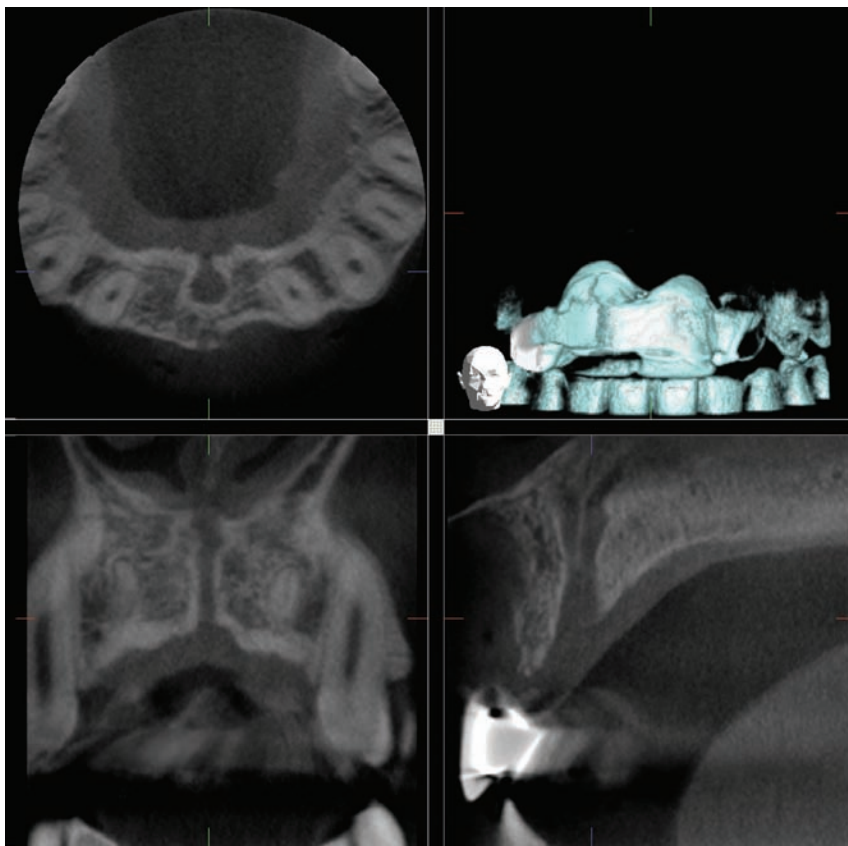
A series of cone-beam CT sections of the incisive canal. The upper left shows the canal in the axial plane, the lower left in the coronal plane, and the lower right in the sagittal plane. The top right is a 3D reconstruction showing the radiographic stent. The incisive canal occupies a larger proportion of the bone volume between the adjacent incisor roots.
